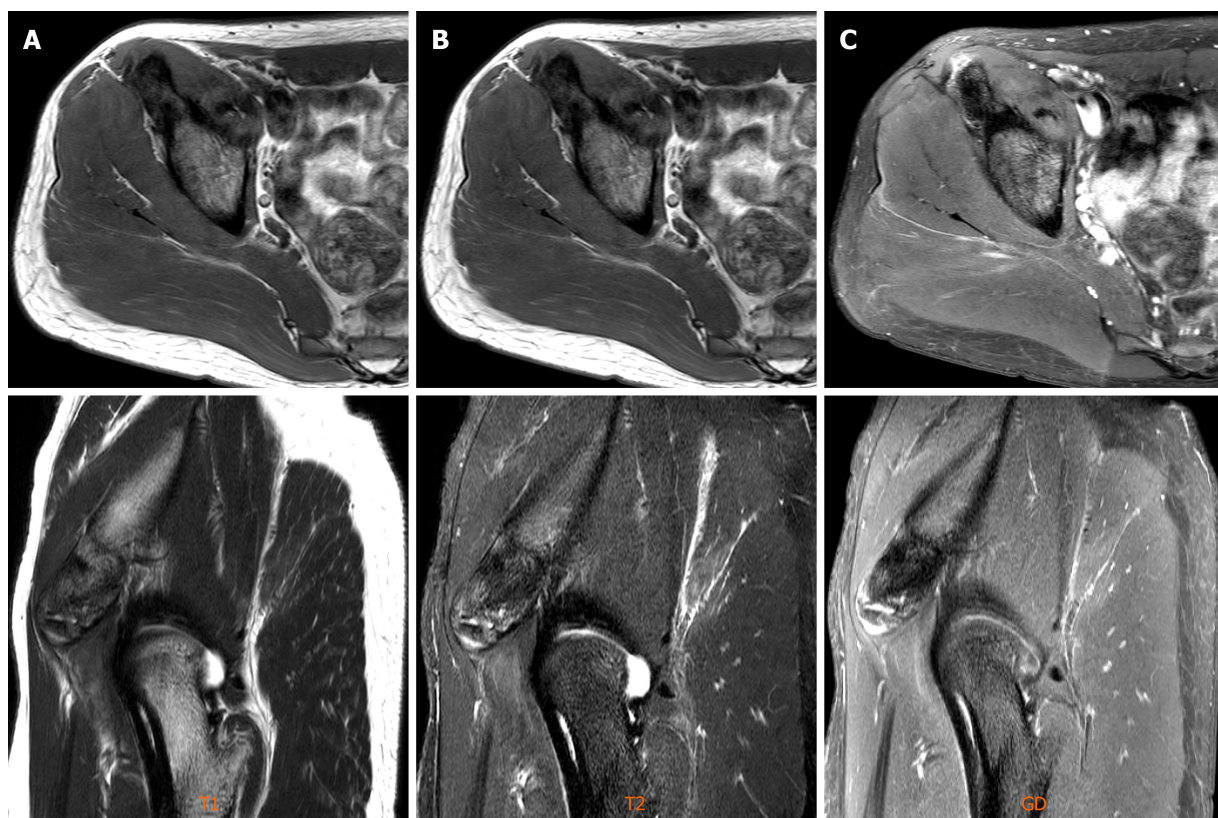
Imaging examinations. A: T1-weighted magnetic resonance images showed low signal intensity in the mass; B and C: T2 mDIXON water magnetic resonance images, gadolinium-enhanced T1 mDIXON water images showing high signal intensity around the mass.
